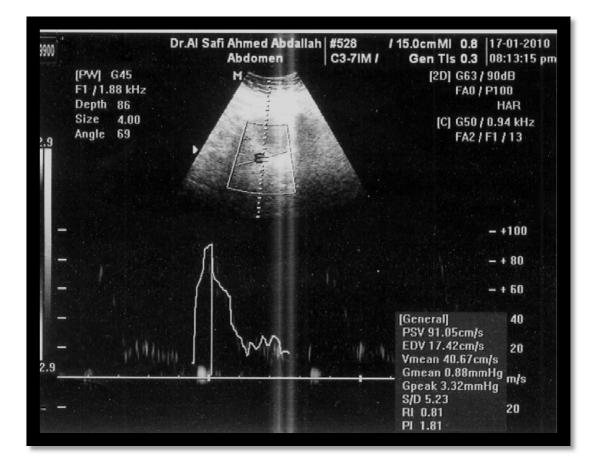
sagittal color Doppler abdomen scan for 35 old patients showing complete
